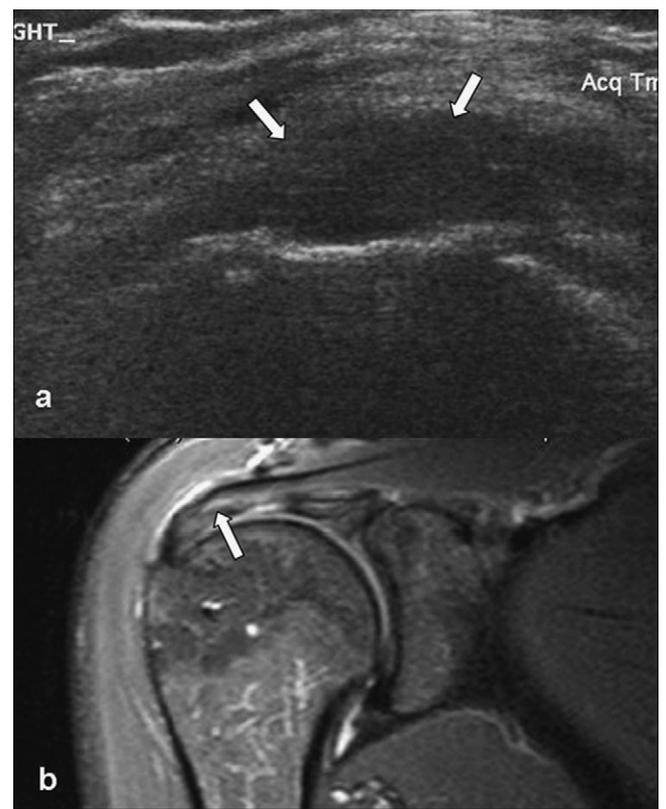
A 56-year-old male patient with clinically suspected rotator cuff tear. (a) The longitudinal sonogram along the course of the supraspinatus, demonstrates a large hypoechoic area extending through the entire substance of the supraspinatus tendon (arrows). A full-thickness tear was diagnosed. (b) The coronal STIR MR image shows high signal intensity at the bursal surface of the supraspinatus tendon (arrow). The diagnosis of a bursal surface partial-thickness tear was confirmed by arthroscopy.
